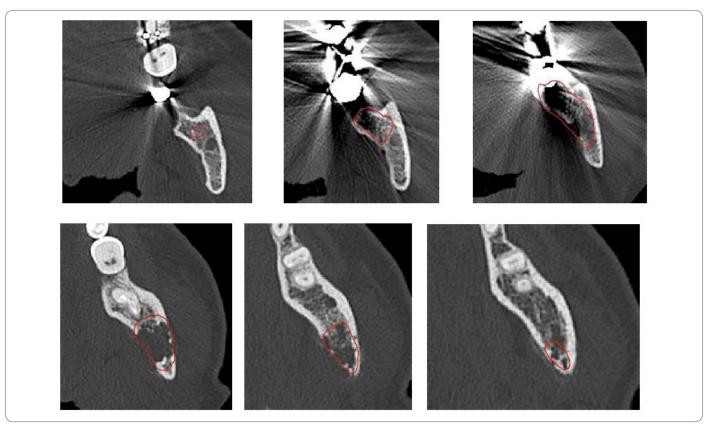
The red line in Axial CT scan showing the osteolytic area into the left mandible ramus.
